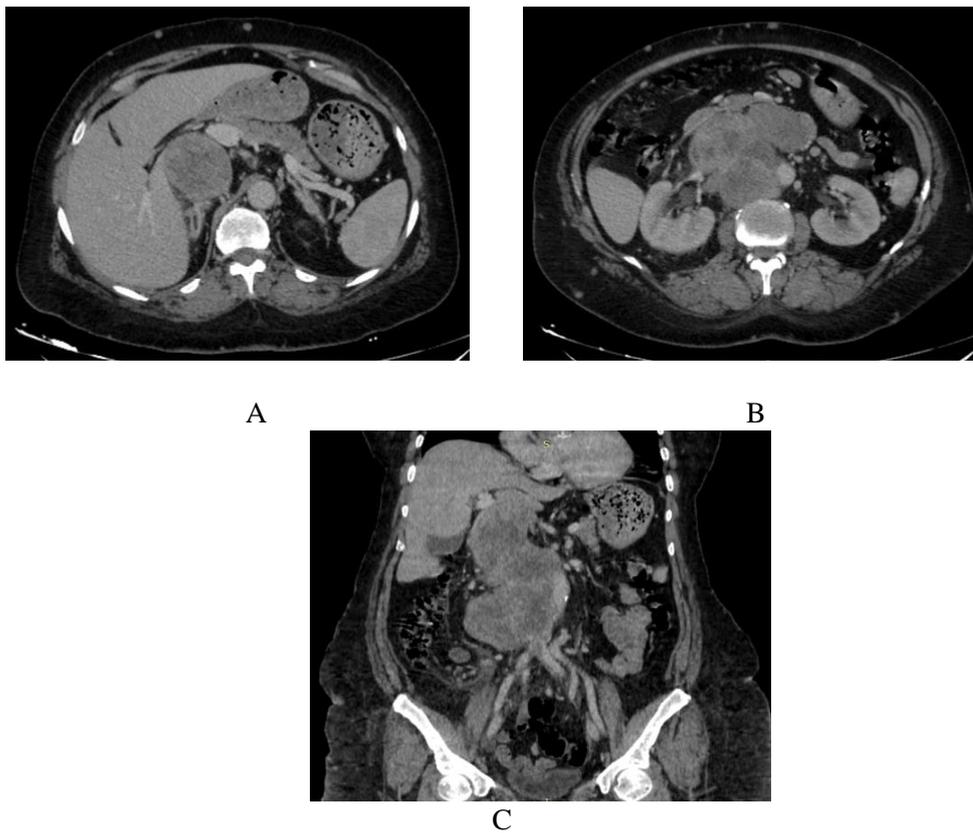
IVC leiomyosarcoma in a 61-year-old female patient complaining of abdominal pain, contrast-enhanced CT at the venous phase axial (A, B) & coronal (C) images show a large well defined lobulated outline retroperitoneal solid mass lesion, measuring about 210x130 mm. The mass is seen invading & extending along the rightward aspect of the IVC (involving its middle & inferior segments from D10 below hepatic veins to L5 confluence of both common iliac veins) sparing its superior segment from the hepatic veins to the Rt. atrium of the heart, having both intra & extra-luminal components. The mass is seen displacing the pancreas anteriorly, with lost in-between fat planes with the aorta, caudate lobe of the liver & the Rt. Psoas muscle. The mass showing extensive areas of necrosis inside. The mass is of moderate vascularity, with heterogeneous enhancement.
